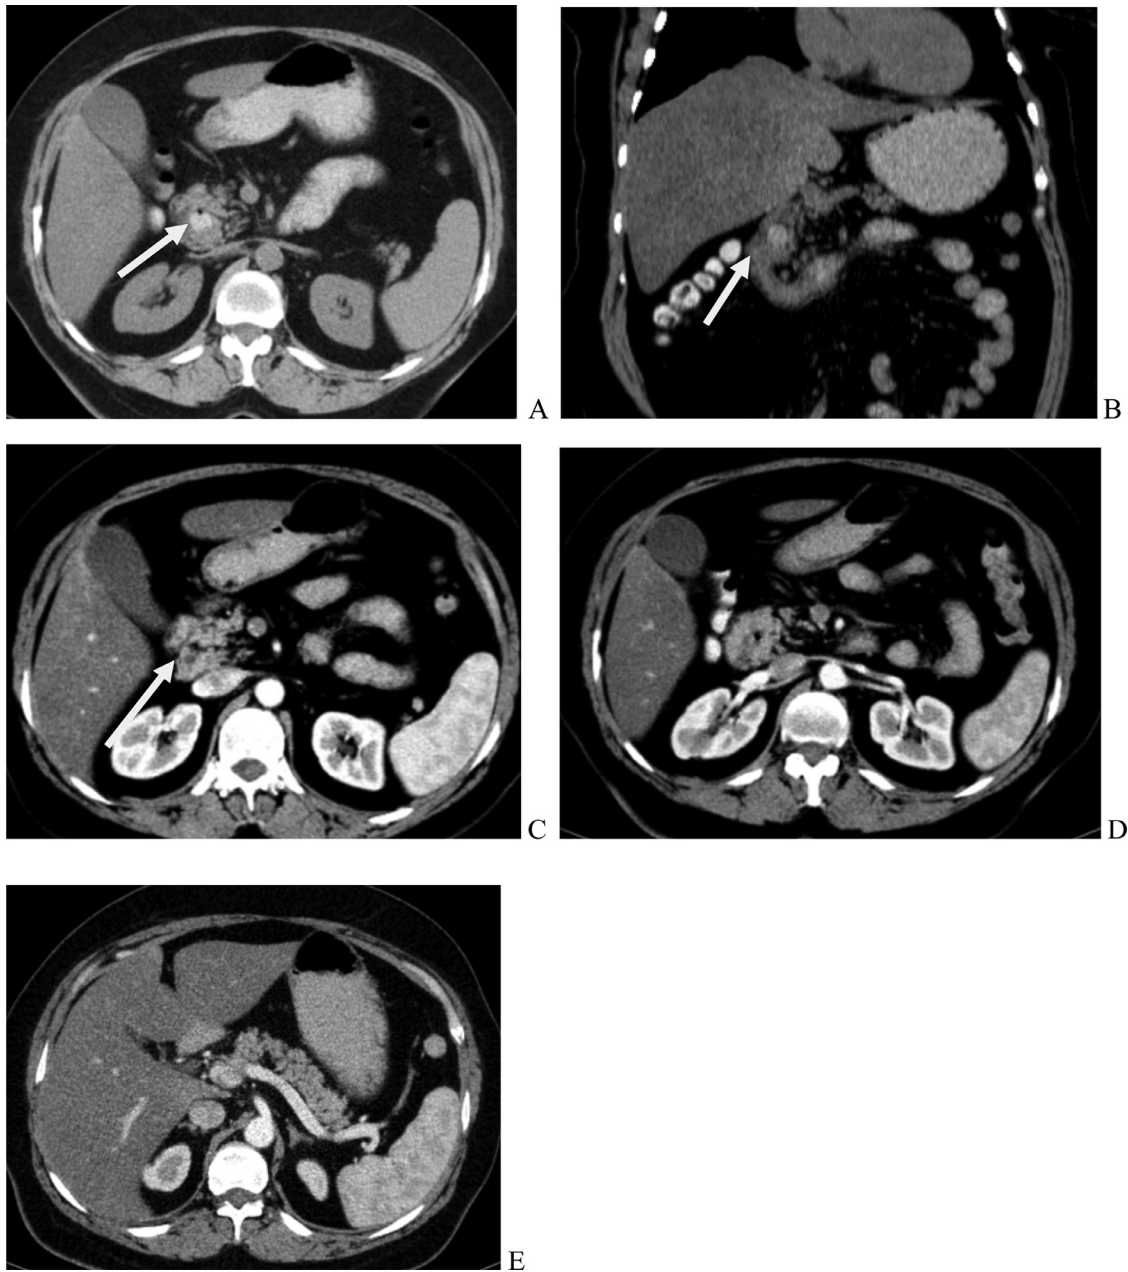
Abdominal CT axial images and coronary reconstruction with per os contrast (A and B) and with intravenous contrast (C and D) present the duodenum surrounded by isodense tissue with the pancreas. In images without i.v. contrast (A and B) notice the contrast applied per os in the duodenum which is surrounded by pancreatic tissue (A, B, white arrows). In the images after the application of contrast i.v. the choledochus with posterolateral position from the duodenum (C, arrow) and air in the duodenum (contrast for os is no longer presented) as well as the homogeneous amplification of the contrast by the pancreatic tissue is observed. There is also diffuse steatosis of the liver as well as another segmented pancreas without pathological changes (E).
